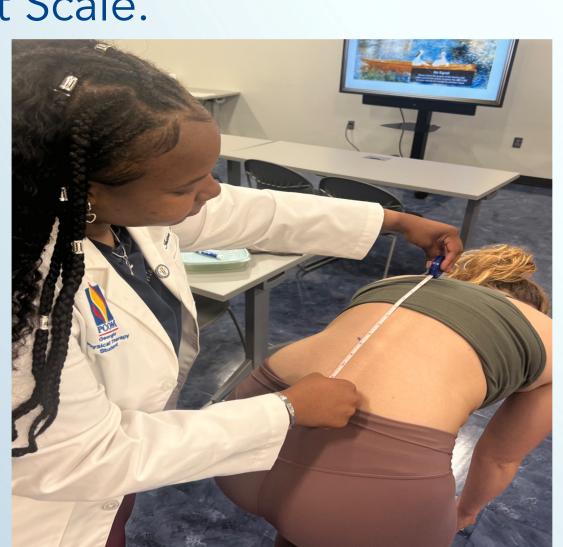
Image on the left is the set up for ultrasound and Vibracool and imaged on the right is the Schober test
